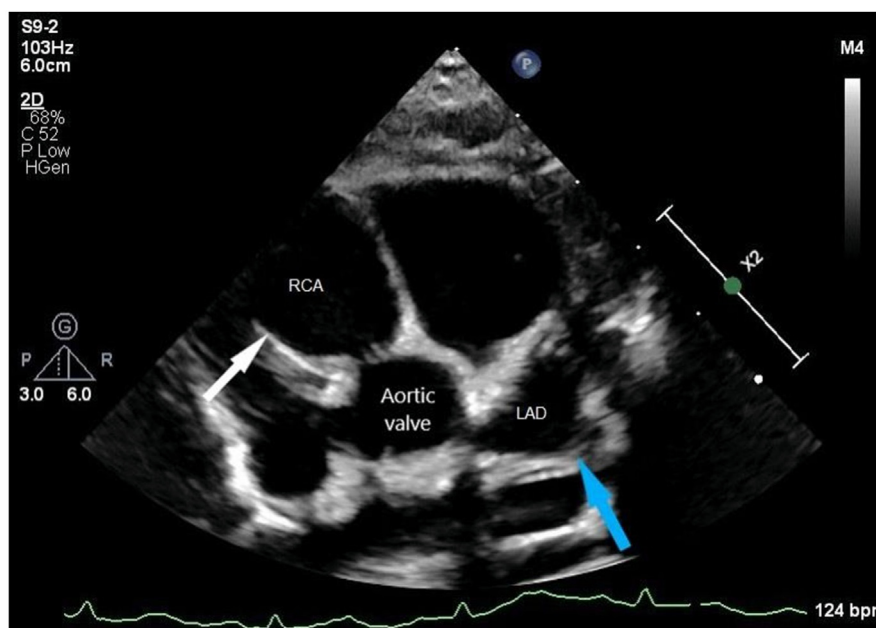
Two-dimensional TTE, basal parasternal short-axis view, demonstrates a giant RCA fusiform aneurysm (white arrow; 16.5 × 24.4 mm; Z score +47.2) with a Z score of +47.18 and normal proximal LMCA with distal LMCA/proximal LAD saccular aneurysm (blue arrow; 6.9 mm; Z score +22.5).
